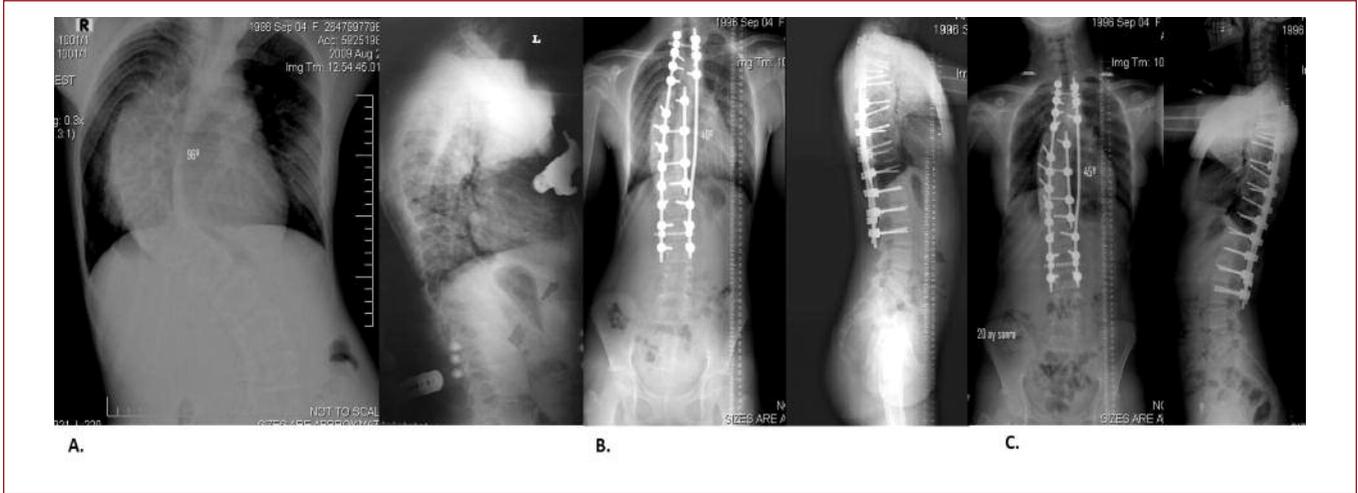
Patient 1 A. antero-posterior and lateral X-ray before surgery B. antero-posterior and lateral X-ray after surgery C. antero-posterior and lateral X-ray after follow-up period.
